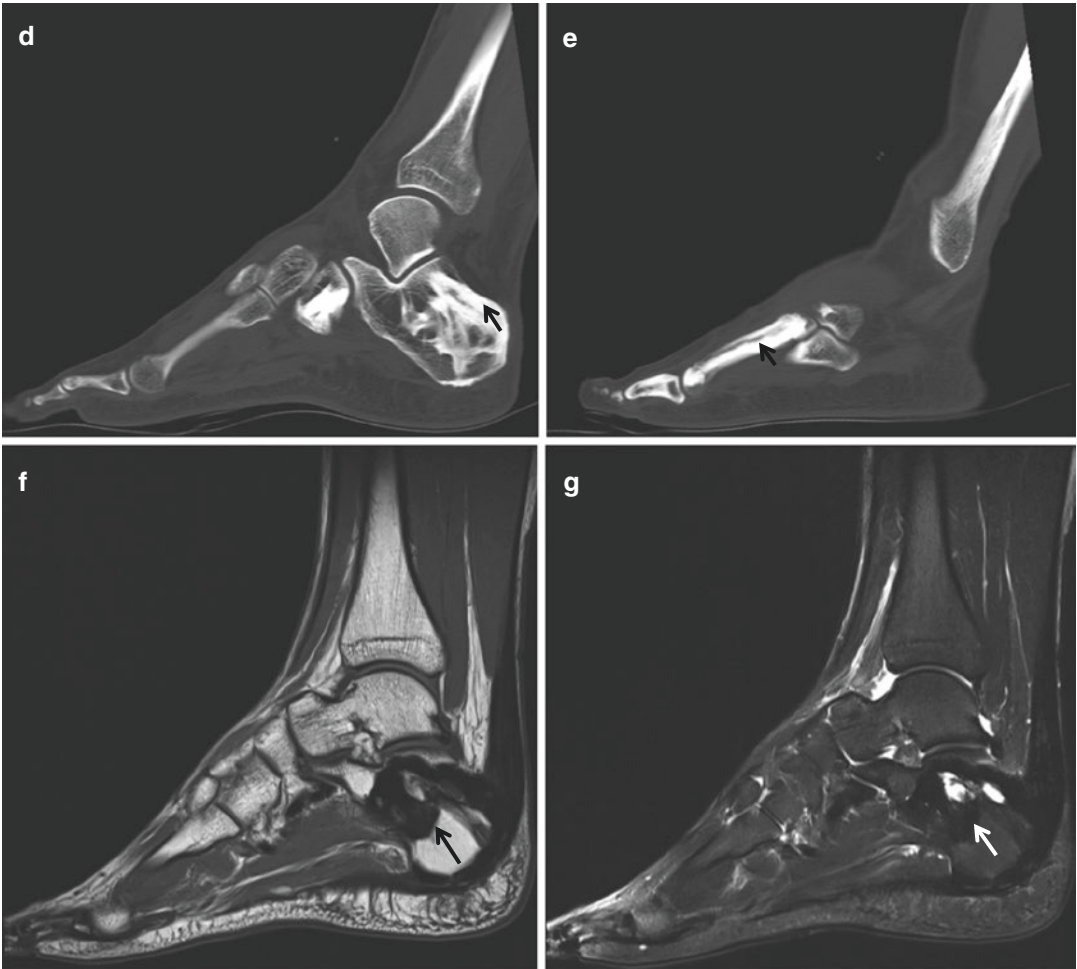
Osteopathia striata. Lateral radiographs of the bilateral ankles show dense linear striations (*arrows*) in the diaphysis and metaphysis of the left tibia
